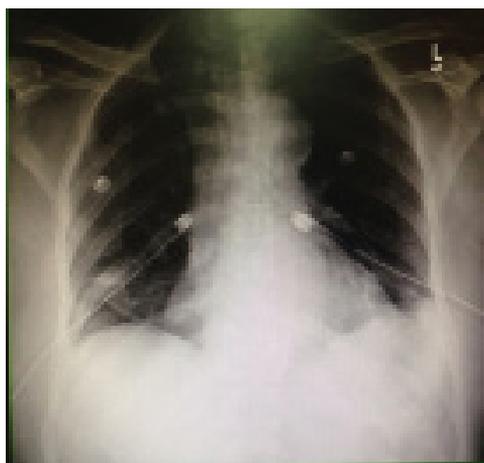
Chest X-ray post bilateral chest tubes insertion showing re-expansion of both lungs
